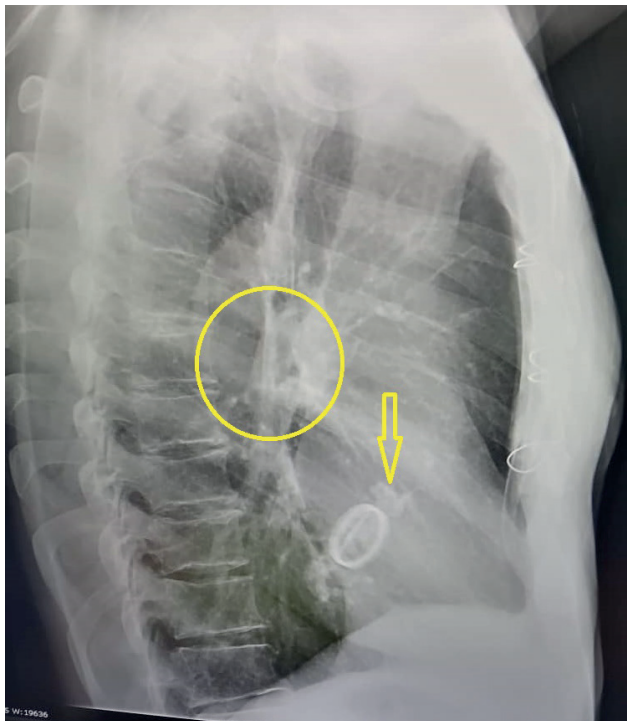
Chest X-ray in right lateral view. The yellow circle indicates the hilar thickening, and the yellow arrow indicates the calcification described in the posteroanterior view.
